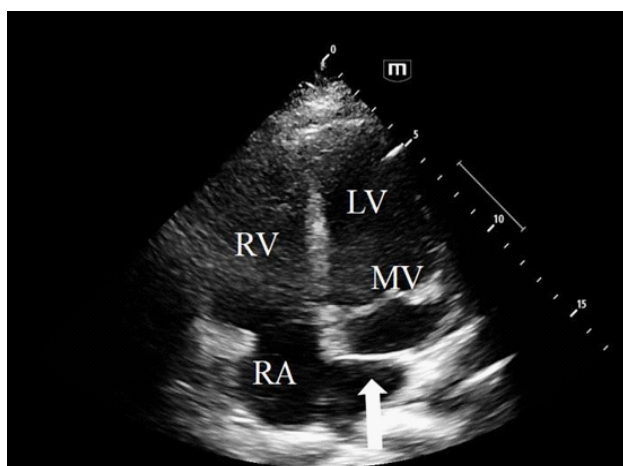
Apical 4 chamber view showing a horizontal flap crossing the left atrial chamber (white arrow). LV, left ventricle, RV, right ventricle, RA, right atrium, MV, mitral valve.
